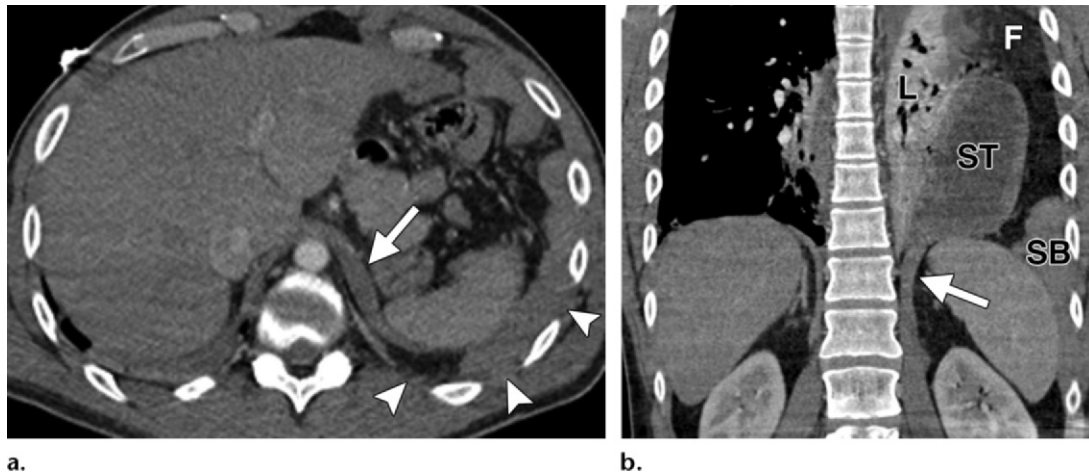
Left-sided BDR in a 36-year-old man after a motor vehicle accident. (a) Axial contrast-enhanced CT image shows thickening of the left diaphragmatic crus (arrow) in comparison with the right crus (thickening of the diaphragm sign). Abdominal fat and small bowel (arrowheads) are seen posterior and lateral to the spleen and the remaining part of the diaphragm (dependent viscera sign, abdominal content peripheral to the diaphragm or lung sign). (b) Coronal contrast-enhanced reformatted CT image at the level of the spleen shows thickening of the left crus (arrow). Parts of the stomach (*ST*), small bowel (*SB*), and omental fat (*F*) have herniated into the thorax and directly contact the collapsed lung (*L*) (herniation through a defect sign, abdominal viscera abutting thoracic fluid or a thoracic organ sign).
